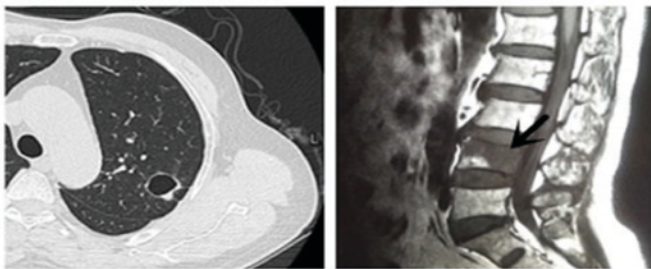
Computed tomography image of thin-wall cystic lung cancer in a 57-year-old male (left). Metastases to the fourth lumbar spine (right).
